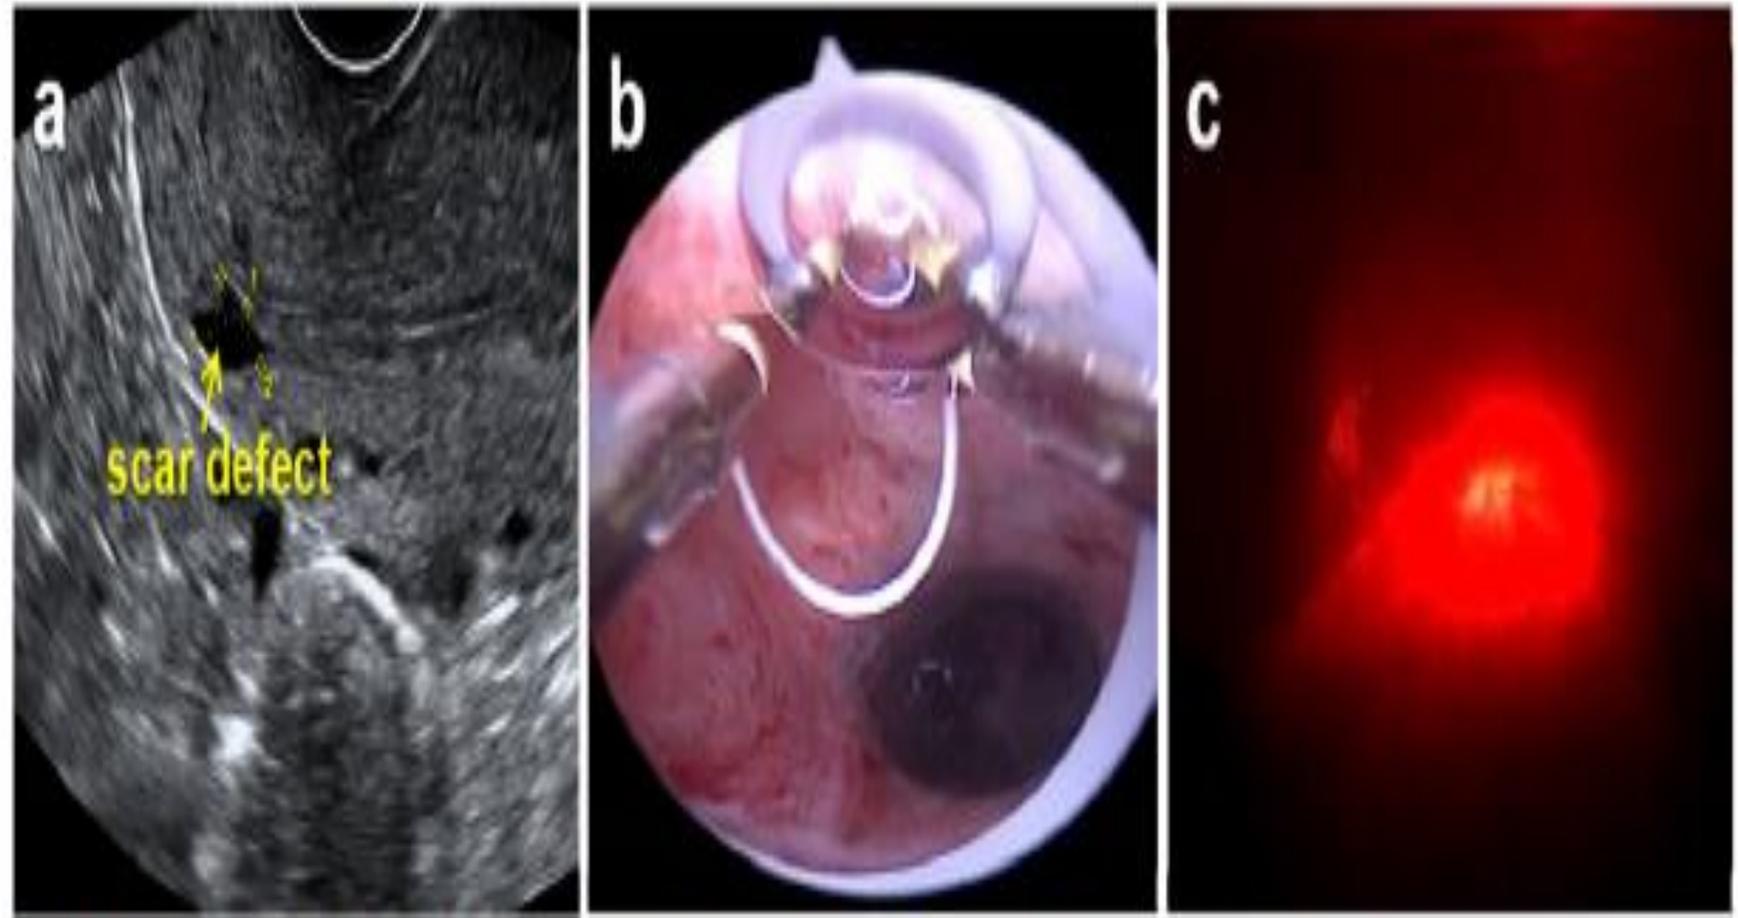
CSD examination and confirmation: a transvaginal ultrasound image; b hysteroscopic examination; c light test
